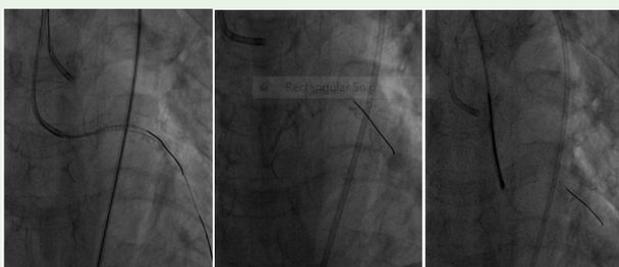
BMW wire was fractured, opaque X-ray segment about 30 mm: middle segment left in LAD between LAD intima and the stent (distal wire fractured).
